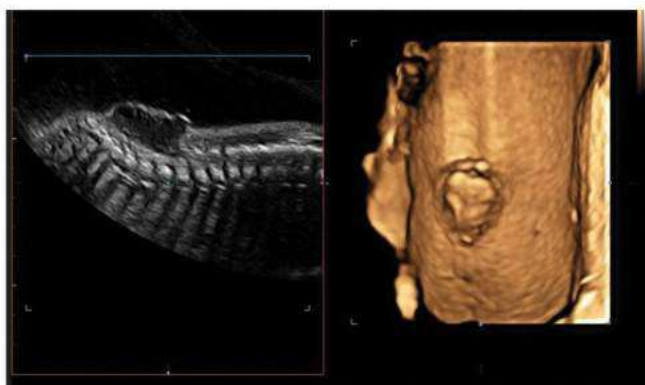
2D and 3D ultrasound image of spina bifida
